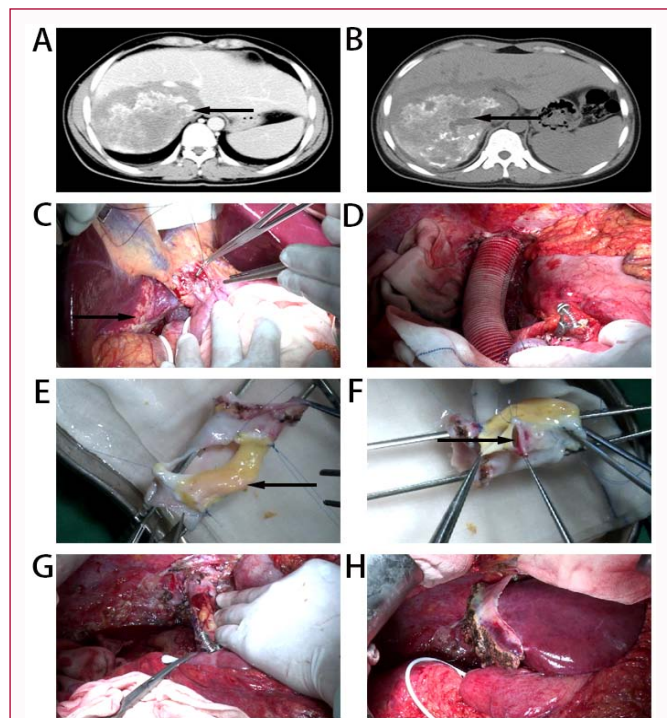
(A) Preoperative enhanced CT scan showed the IVC invaded by the lesion. Black arrow shows IVC. (B) Preoperative enhanced CT scan showed the hepatic AE lesion located in the right posterior lobe and caudate lobe of the liver. Black arrow shows hepatic AE lesion. (C) ELRA for the treatment of hepatic end-stage AE. Black arrow shows the lesion. (D) Reconstruct the hepatic IVC with artificial vessels to perform a temporary portal shunt. (E) Using disease-free IVC and the umbilical vein within the LTH to reconstruct the IVC. Black arrow shows the umbilical vein within the LTH. (F) Using disease-free IVC and part of the PV to reconstruct the IVC. Black arrow shows the PV. (G) The IVC was replanted back into the abdominal cavity after complex reconstruction. (H) After meticulous dissection, left lateral lobes were replanted back to the abdominal cavity.
